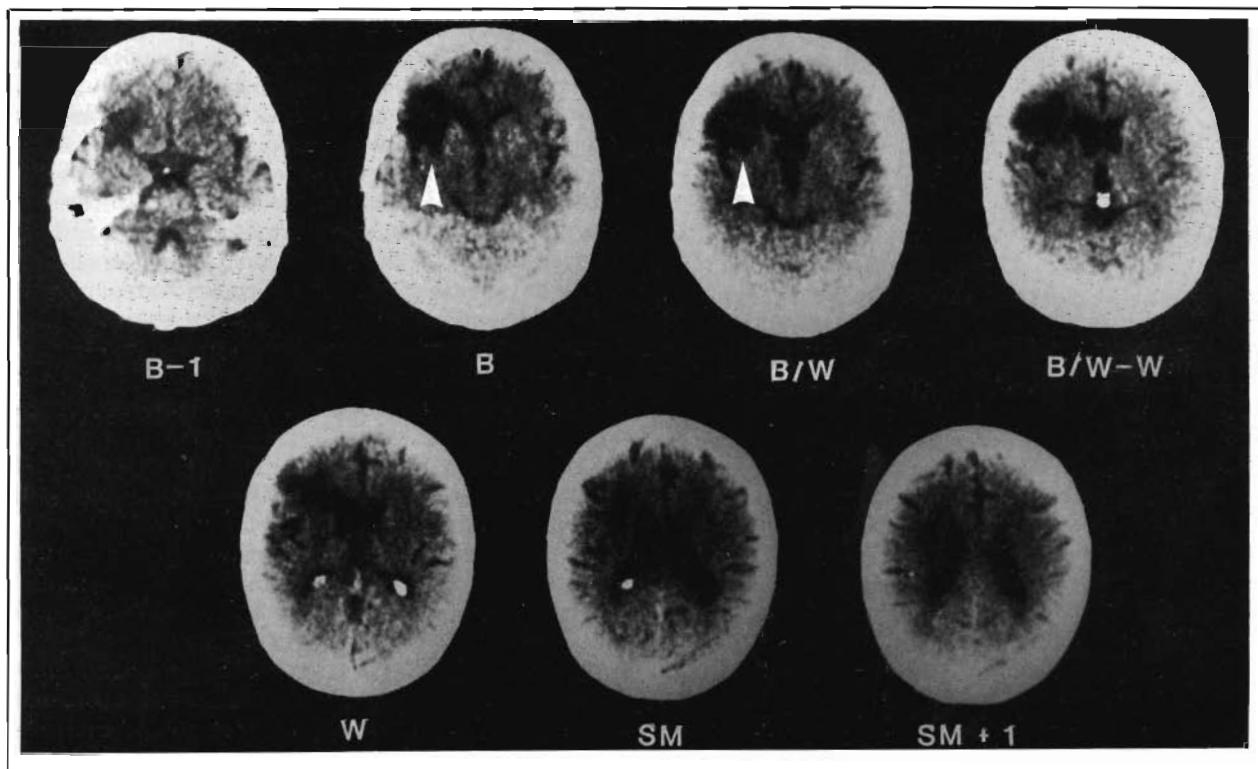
CT of TCM aphasia case with mild auditory comprehension problem. In addition to lesion, which is anterolateral to left frontal horn, there is lesion in the anterior portion of the head of the caudate (slice B/W-W) and lesion extension across the anterior limb internal capsule, anterior putamen, and anterior portion of the external capsule, claustrum, extreme capsule, and insula (slices B and B/W, arrows). Patient 9, aged 65, 1 month postonset. This patient, in addition to having a mild comprehension problem, also had poor articulation. Note superior lesion extension into the descending pyramidal pathways for face, lips, and tongue area in the periventricular white matter at slices SM and SM+1. (See also figure 4.)
